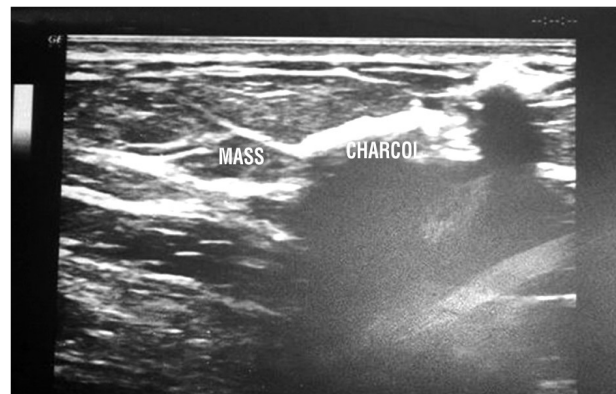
Ultrasound picture after injection of charcoal at the superficial margin of suspicious lesion BIRADS 4b measured 12.5X6 mm & forming a track between the suspicious lesion and the point of needle entry in the skin in patient aged 41 years with positive family history of breast cancer
